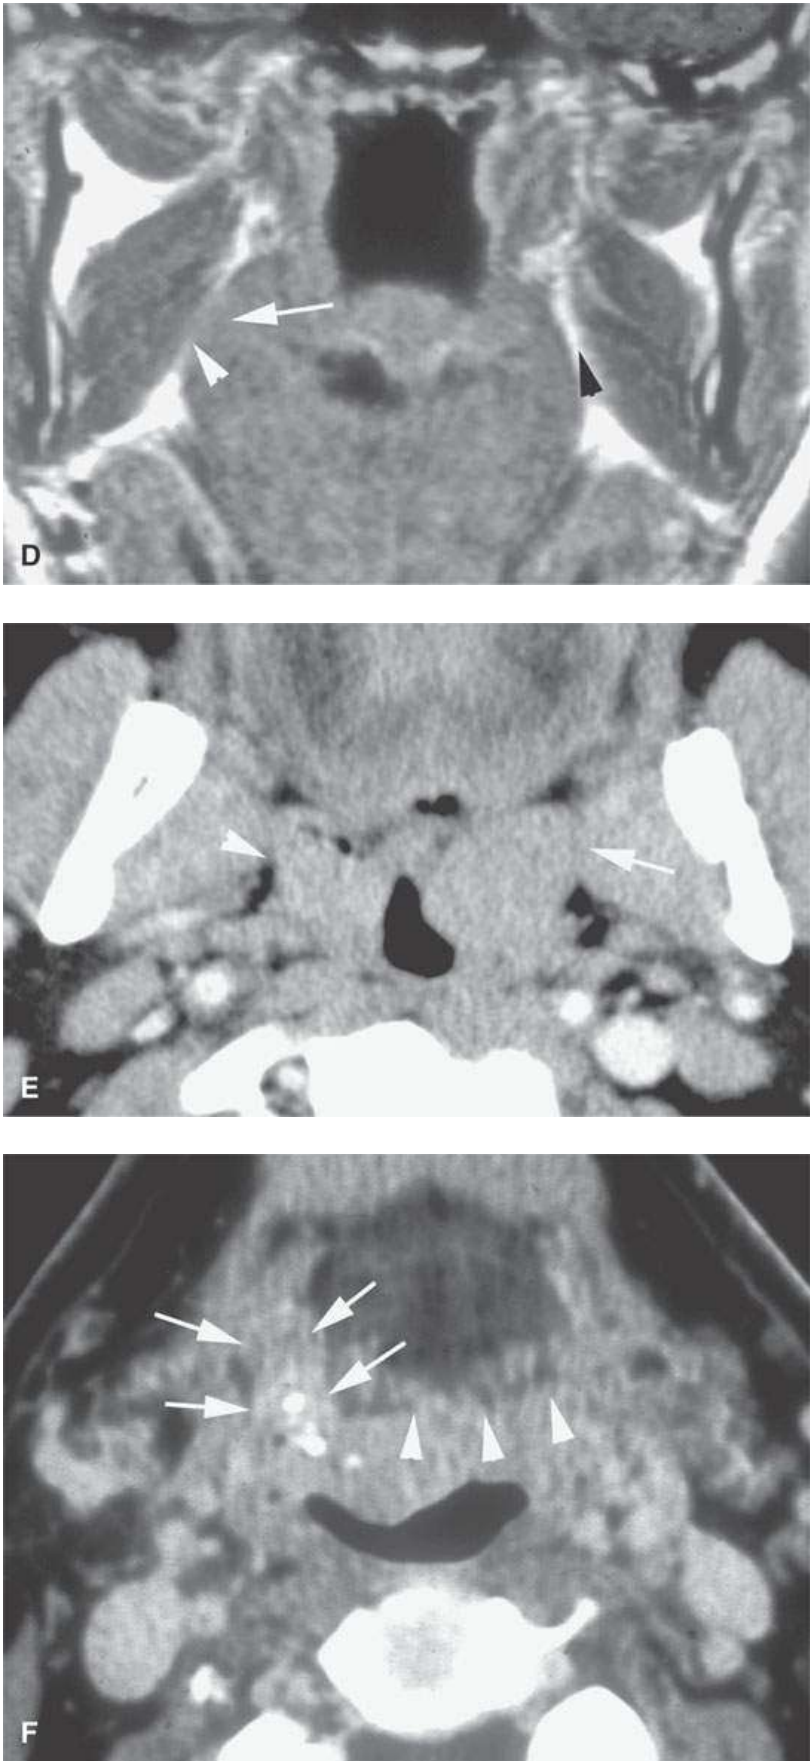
Three patients with submucosal cancers not visible to the endoscopist. A–D: Magnetic resonance imaging of a patient presenting with right-sided otalgia and no visible mucosal lesion—all pulse sequences show the enlarged right palatine tonsil (*arrows*) with obliteration of parapharyngeal fat on the right (*white arrowheads*) compared to the left (*black arrowheads*). E: Contrast-enhanced computed tomography (CT) of a patient with left level 2 neck node needle biopsy showing squamous cell carcinoma (SCCA). The CT shows a prominent left tonsil with subtle encroachment on the parapharyngeal fat (*arrow*) compared to the normal side (*arrowhead*). F: Contrast-enhanced CT of a patient with right-sided otalgia and a right level 2 neck node needle biopsy showing SCCA. The submucosal tongue base cancer penetrates (*arrows*) the tongue base to a far greater degree than the normal carpet of lingual tonsillar and other glandular tissue (*arrowheads*).
